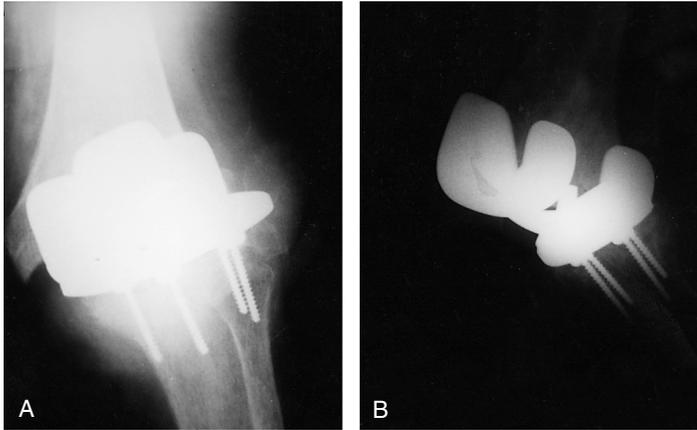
(A) Anteroposterior and (B) lateral radiographs of a 54-year-old man with an infected total knee arthroplasty.
